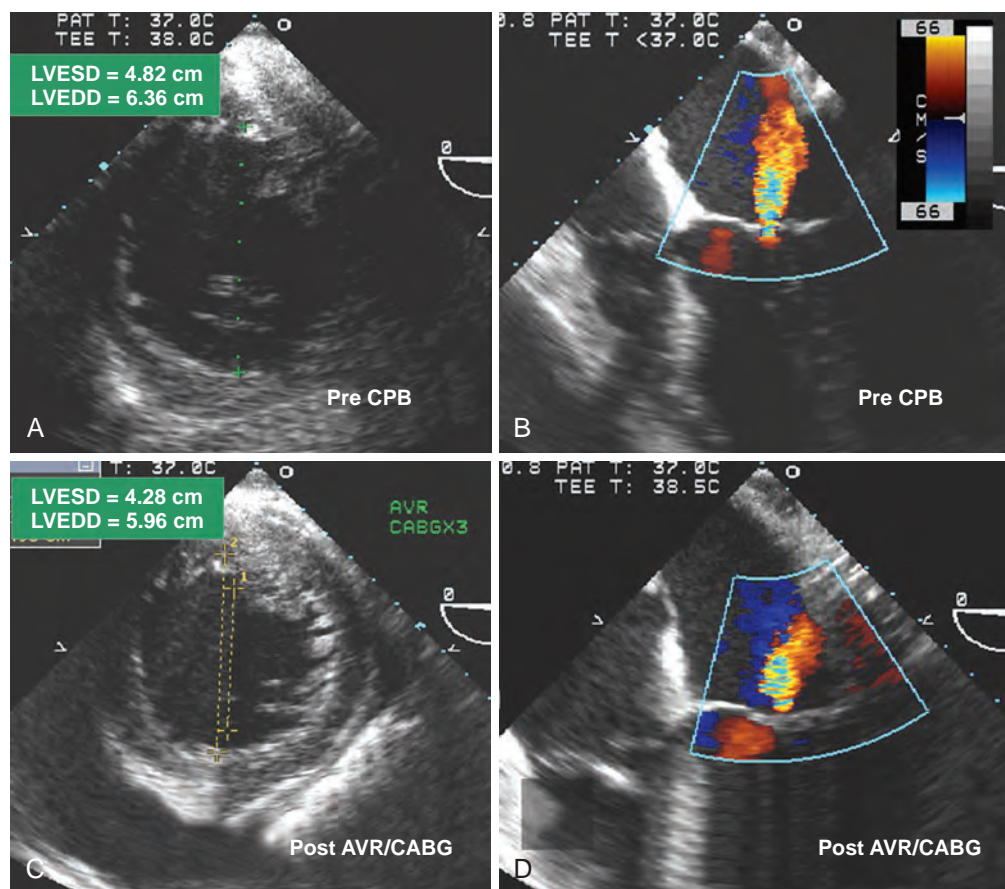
Management of concurrent mitral regurgitation (MR) in a patient undergoing aortic valve replacement (AVR) for aortic stenosis (AS). This 70-year-old patient underwent an AVR for critical AS. The patient had history of hypertension, moderate MR, congestive heart failure, and episodes of shortness of breath. (A) Left ventricular (LV) function was moderately depressed, and the chamber size was dilated (LV end-diastolic dimension [LVEDD] = 6.36 cm). (B) The patient had a central jet of MR that was graded as mild; the annulus was mildly dilated, and the pathologic features of the leaflets and apparatus were only mildly thickened. The pulmonary vein blood flow showed minimal blunting of the systolic component, consistent with increased left atrial pressures but not clinically significant MR. The discrepancy in the severity of MR between the preoperative study and intraoperative transesophageal echocardiography (TEE) reflects the effect of general anesthesia on loading conditions. After reviewing the prebypass TEE examination and the patient's history, it was decided to perform only an AVR. A bioprosthetic valve was chosen by the surgeon because of the patient's age, thus eliminating the requirement for anticoagulation. Because the MR was believed to be more functional, the replacement of the severely stenotic AV, the major pathologic lesion, was anticipated to decrease MR over time. The choice of implanting a no. 23 pericardial prosthetic valve was based on the annular size that was measured before initiation of bypass. (C) and (D) The postbypass TEE examination documented that the gradient across the AV decreased from 74 to 18 mm Hg, and (C) cardiac function and (D) MR improved after AVR.
